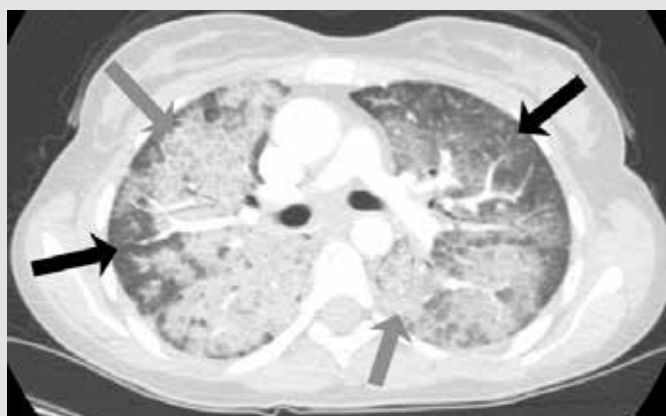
Axial CT scan shows dense air-space disease, with relative sparing of the sub-pleural rim of the lung peripherally (black arrows), and a superimposed interstitial pattern of thickened secondary lobular septa. The typical consolidation of alveolar proteinosis is best seen within the right lung with a 'crazy-paving' appearance (grey arrows).
